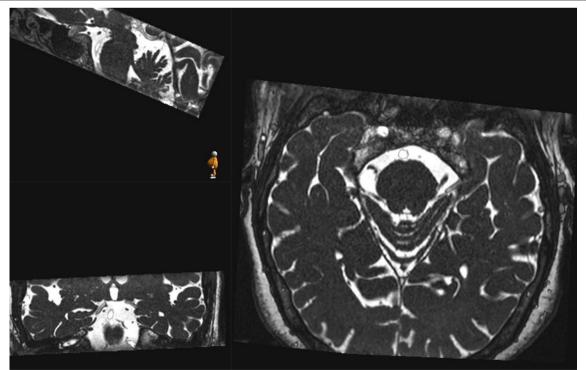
Preoperative axial MRI with constructive interference in steady state showing an offending vascular loop near the right trigeminal nerve complex with reconstruction in the sagittal/coronal plane
